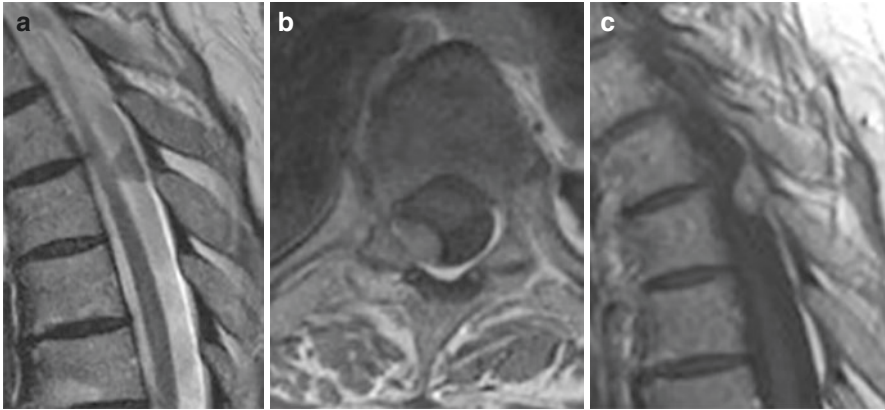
Meningioma. sagittal T2-weighted (a) and sagittal (b) and axial contrast enhanced T1-weighted (c) images demonstrate well-circumscribed mass in the posterior right aspect of the spinal cord with a “tail” into the adjacent dura
